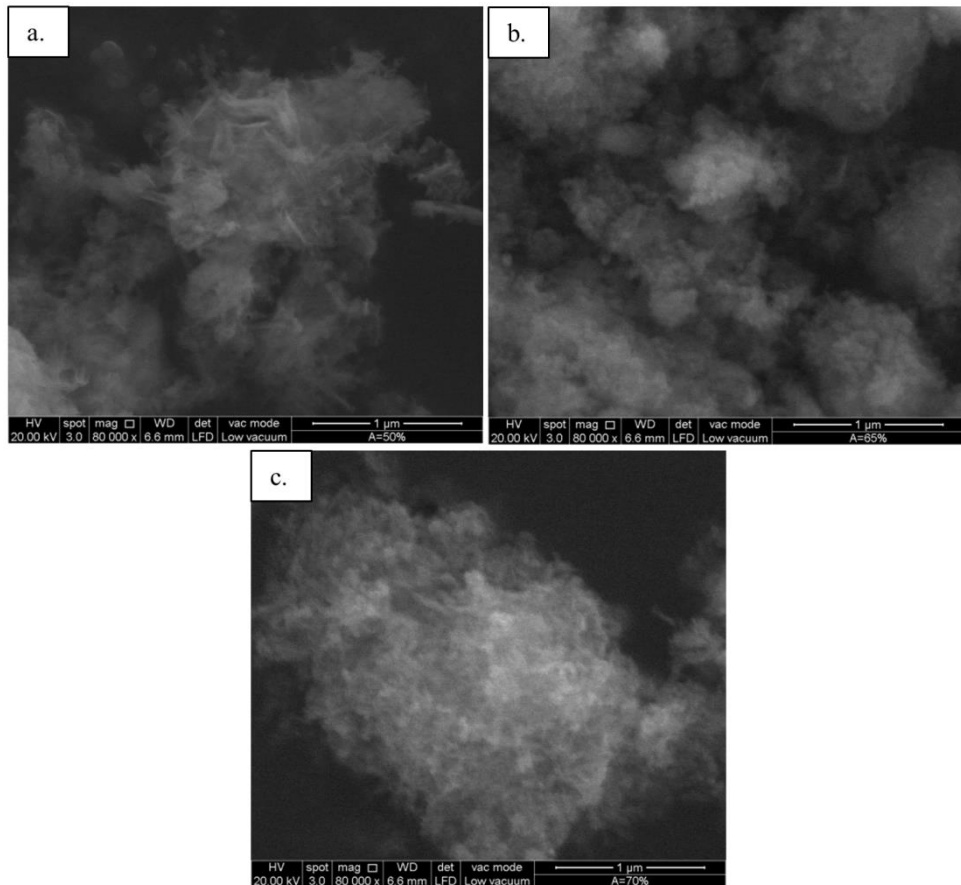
Microstructural images of NHA synthesised at an ultrasonic amplitude of (a) 50%, (b) 65% and (c) 70%
